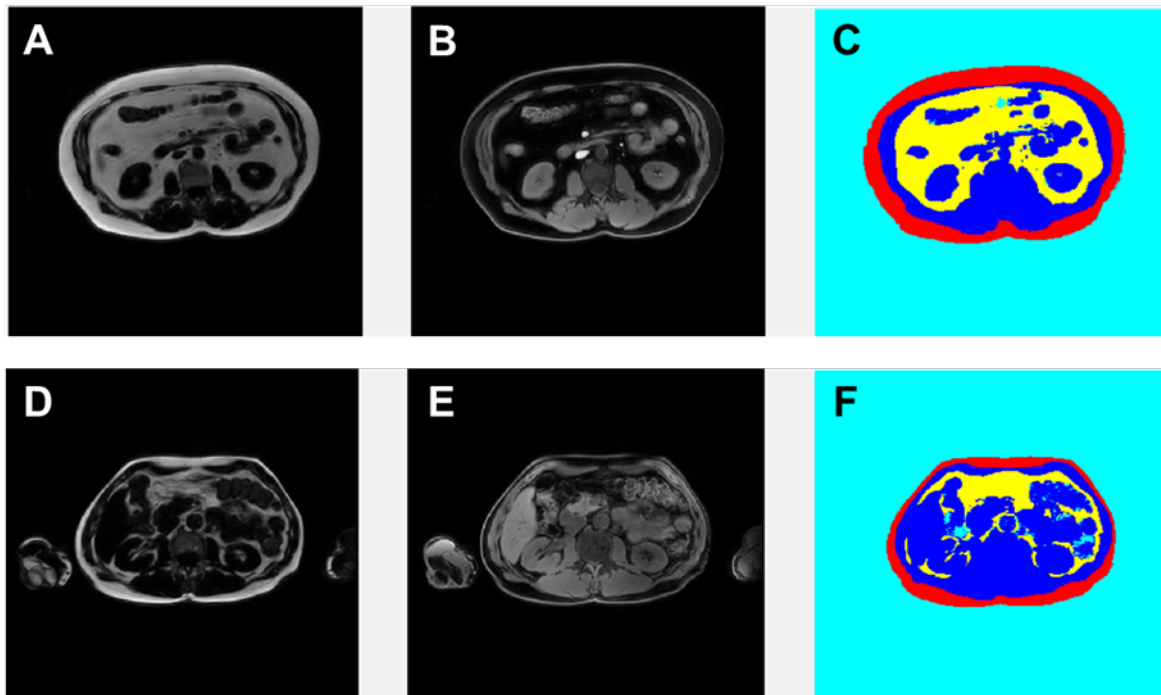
Representative MR images of a 2-point Dixon water-fat image. (A) and (D) are fat images where fat is presented in white. (B) and (E) are water images where fat is presented in black. (C) and (F) are automatic segmentation images of SAT and VAT. SAT is presented in red, VAT in yellow, non-adipose tissue in dark blue and air/bone in cyan blue. (A – C) Obese subject with a BMI of 29.20 kg/m², 8.1 L SAT and 6.6 L VAT. (D – F) Lean subject with a BMI of 23.23 kg/m², 3.5 L SAT and 1.6 L VAT.
